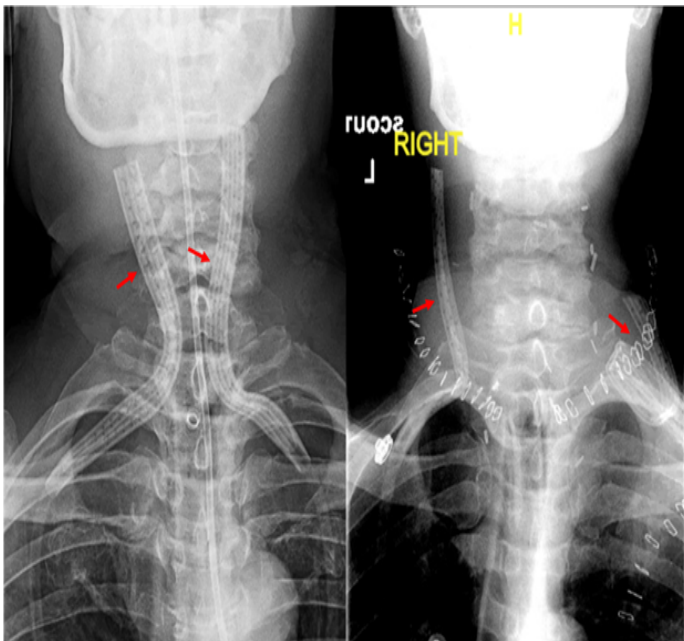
The left image shows a scout radiograph following total laryngectomy with non-displaced JP drains (red arrows). The right image shows a scout radiograph following total laryngectomy with displaced JP drains.
